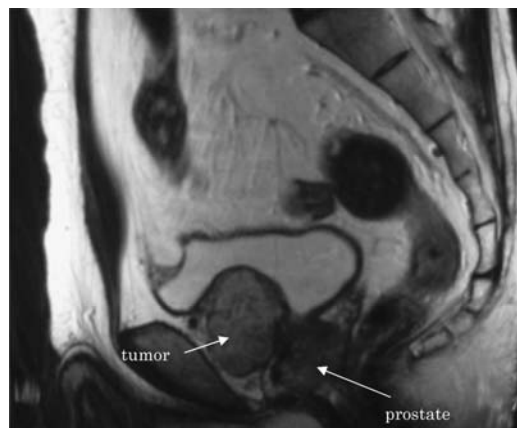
MRI revealed a perivesical tumor, and the space can be seen between the tumor and bladder or prostate.
